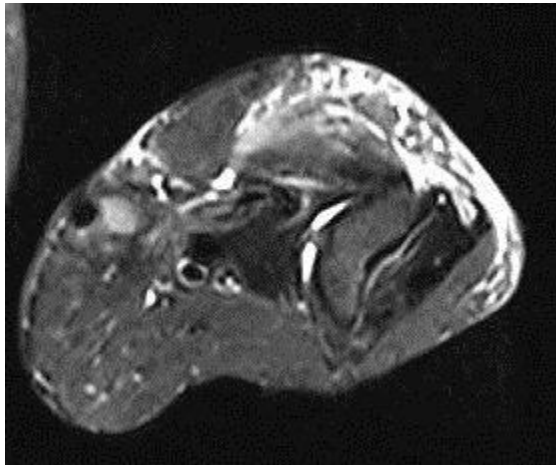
Axial MRI T2 image with radio enhancing lesions in muscle belly and the overlying fascia
